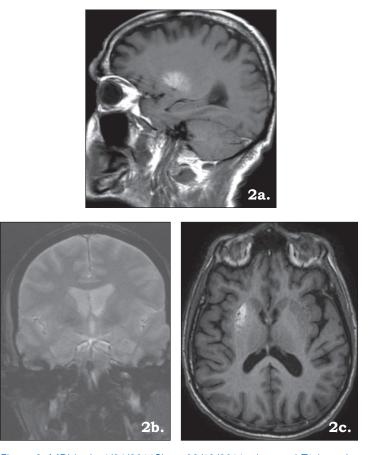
MRI brain 4/24/2014Since 03/19/2014, abnormal T1 hyperintensity has developed in the right right putamen, axial (a) and sagittal (b). Little or no associated signal alteration can be identified on other pulse sequences, GRE (c).
